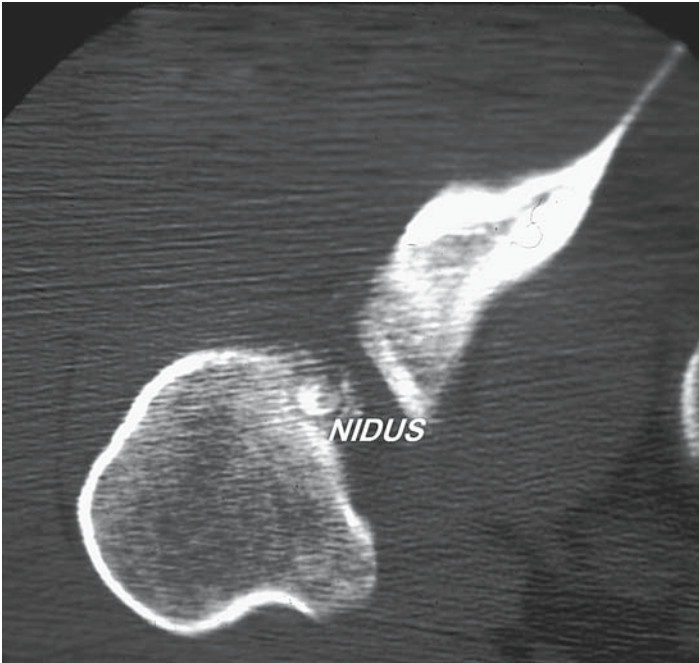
Osteoid osteoma. CT scan demonstrating an intracortical (nidus) osteoid osteomas of the proximal humerus. Osteoid osteomas are small (less than 1 cm), characteristically painful, and usually found in young patients.
